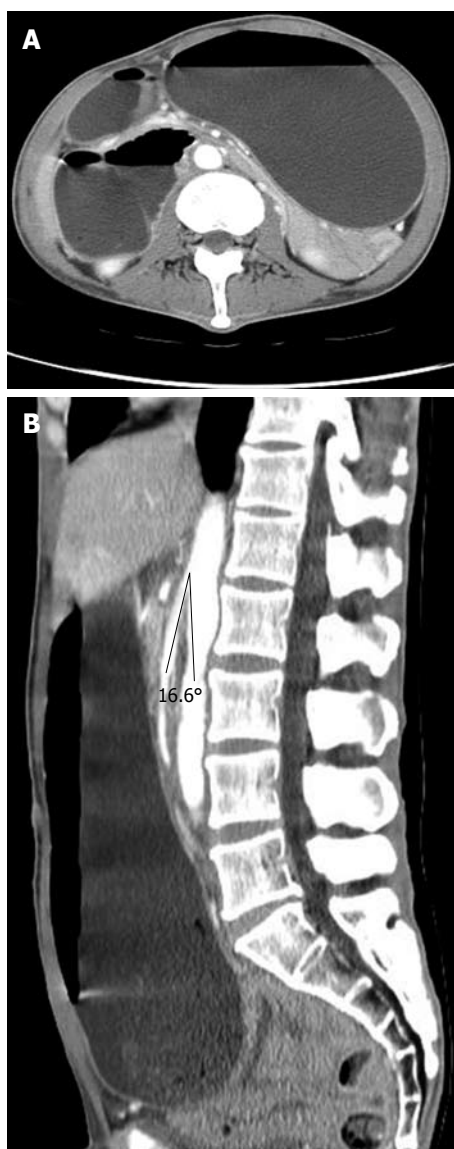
Computed tomography (CT) scan showing distended stomach and 2nd portion of duodenum (A); The angle between aorta and superior mesenteric artery (SMA) was 16.6° (B).
